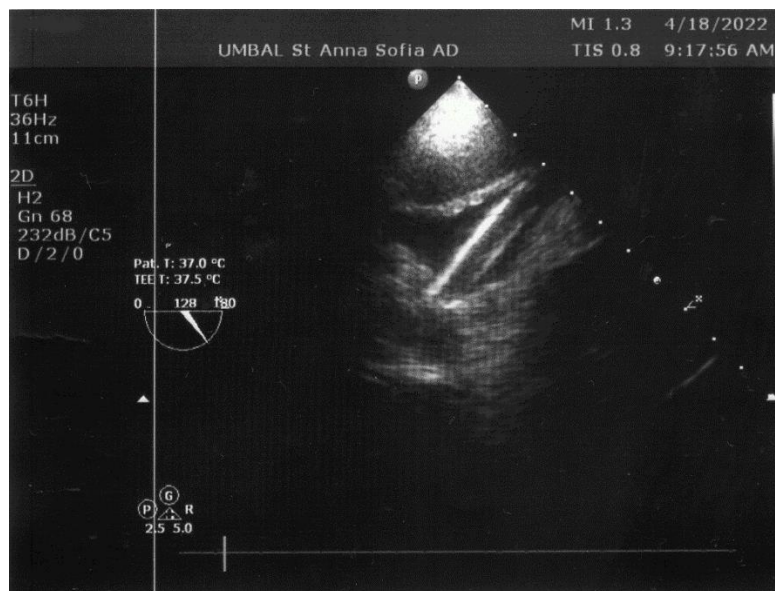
Intraoperative transesophageal echocardiography verifying the positioning of the arterial cannula in the true aortic lumen.
